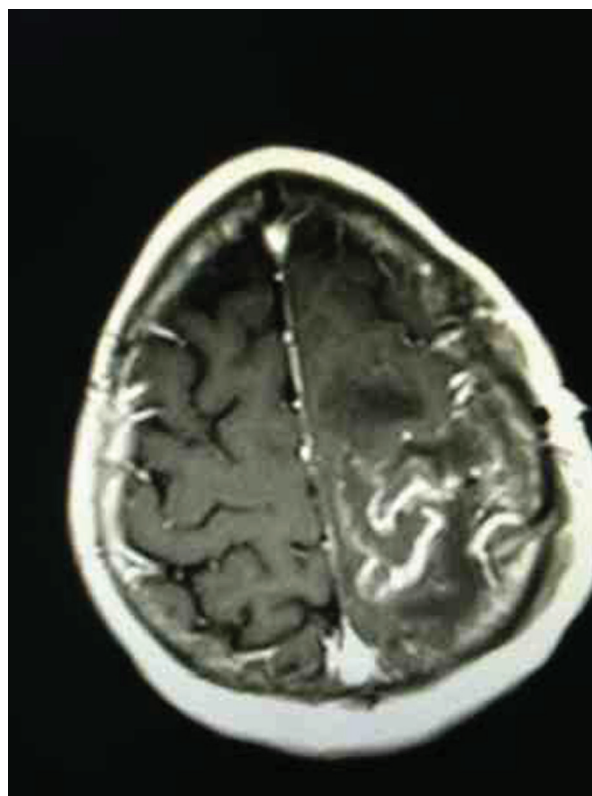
Postop MRI T1-weighted brain.
